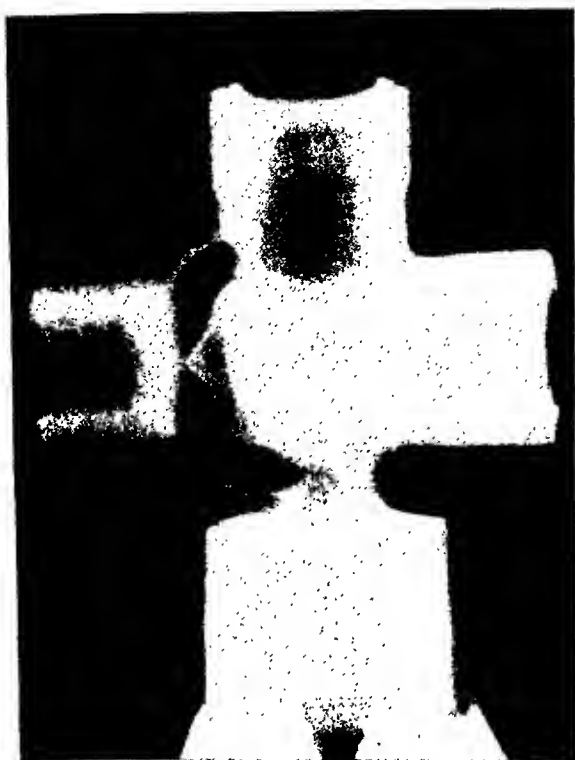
Radiograph of bronze valve casting shown in Figure 6. Distance, source to film, $27\frac{1}{2}$ inches; exposure, 1,600 milligram-hours; two lead screens; one film. Several flaws are visible in the original film.
